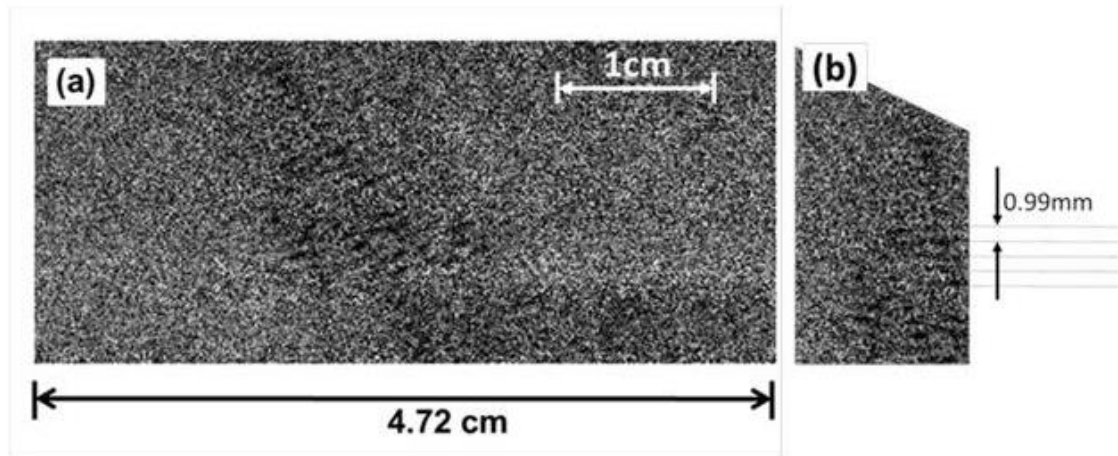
(a) ABI of the whole ultrasound beam of a therapeutic ultrasound system at 0.8835 MHz and 14 W and (b) the sequence and location of cavitation bubbles, with approximately the same interval between sequences. From Izadifar et al. [133]
